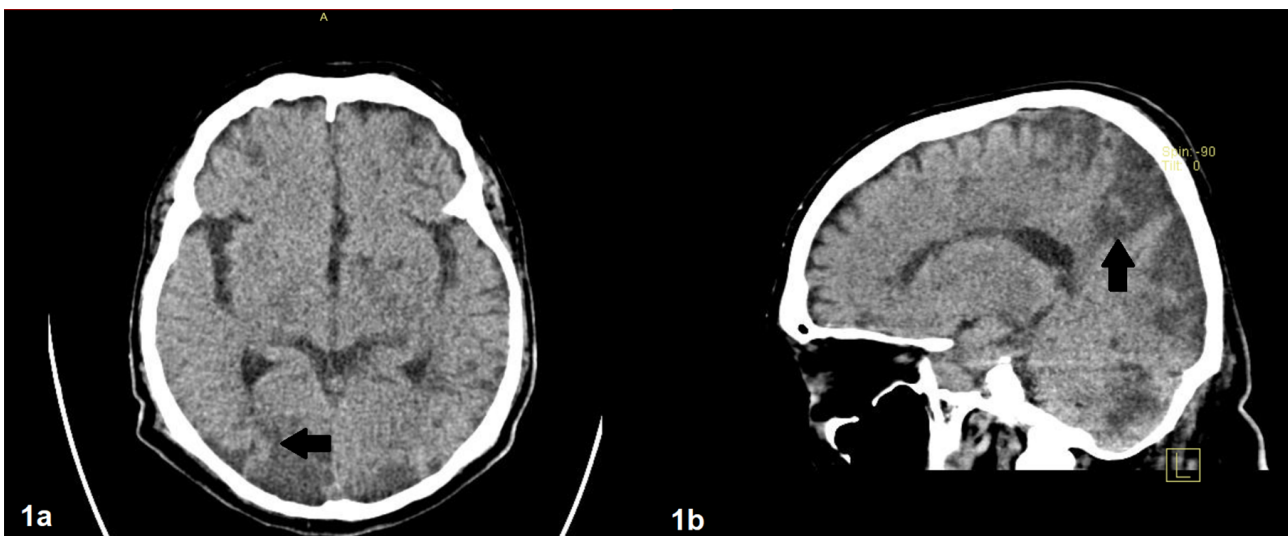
Brain CT showing extensive cerebral infarctions. Hypodensities of the white and gray matter in both cerebral hemispheres are observed in bordering territories, with hypodensities in the posterior fossa and brain stem (arrows). There are no subdural or epidural hematoma, nor subarachnoid hemorrhage. The size and morphology of the ventricular system are normal.
